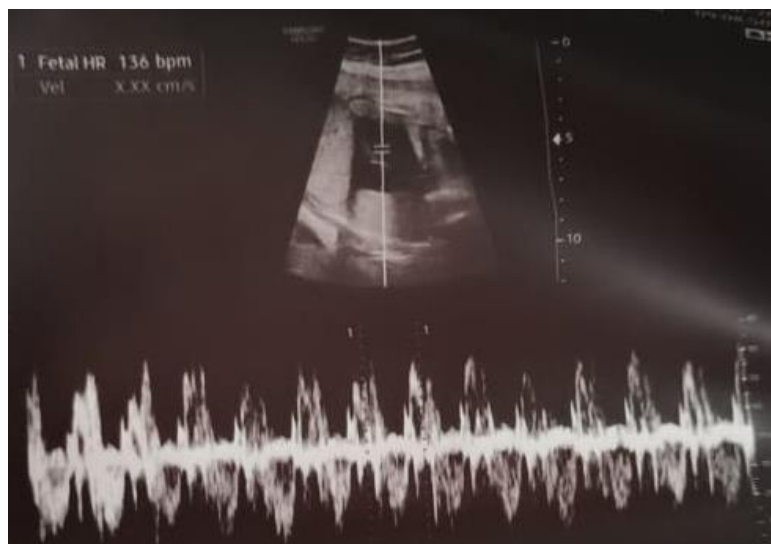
A transabdominal ultrasound done at 28 weeks of gestation showed a normal foetal heart rate with no episodes of foetal bradycardia observed.
